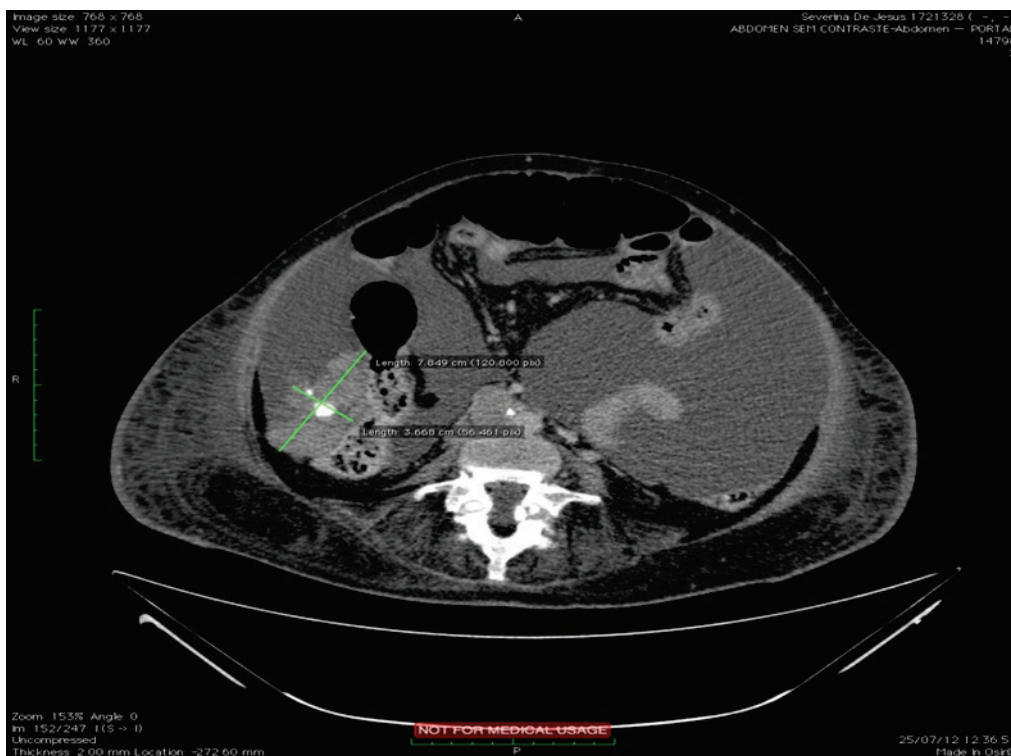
Computed tomography showing secondary peritoneal implantation in the right lower abdomen
